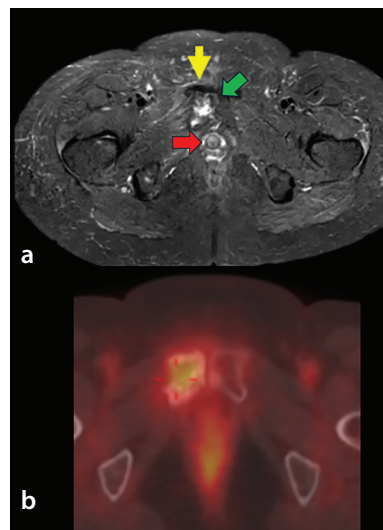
(a) Axial fat-suppressed T2-weighted (DP-FS) MRI of the pelvis demonstrating a hyperintense osteolytic lesion (yellow arrow) involving the right pubic bone. The anatomical relationship to adjacent critical structures, including the urethra (red arrow) and pubic symphysis (green arrow), was a key factor in selecting a non-thermal ablation approach (IRE). (b) Axial fused PET/CT image of the pelvis showing intense FDG uptake in a lytic lesion of the right pubic bone, consistent with metabolically active bone metastasis. DP-FS, dual phase fat suppression; IRE, irreversible electroporation; PET/CT, positron emission tomography/computed tomography; FDG, fluorodeoxyglucose; MRI, magnetic resonance imaging.
